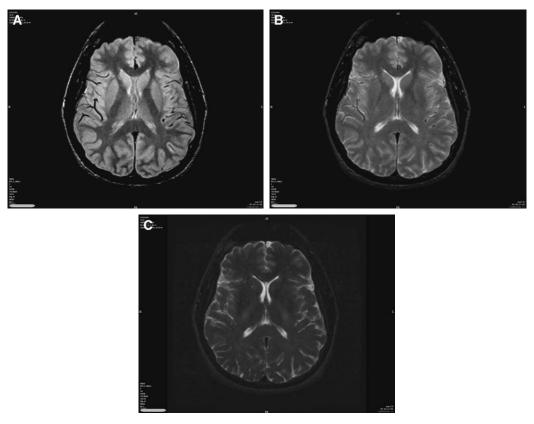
A patient studied with Carr-Purcell-Meiboom-Gill sequence, multiecho, T2-weighted images with echoes at 31, 81, and 160 milliseconds. (A) At the lower echo time (TE; 31 milliseconds), the best gray/white differentiation is achieved. Notice that the white matter is relatively dark compared with the gray matter at a TE of 81 milliseconds (B) and 160 milliseconds (C). With an extremely long TE, however, the cerebrospinal fluid is prominently displayed, but there is loss of the gray/white differentiation.
